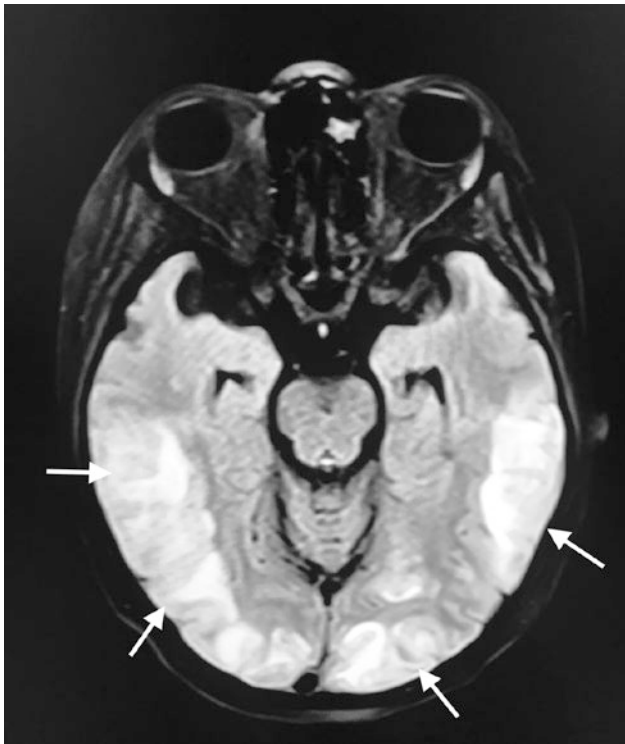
MRI head demonstrating symmetric large confluent areas of abnormal parenchymal T2 FLAIR hyperintense signal (white arrows) prominently involving bilateral temporal lobes (lateral aspects), and bilateral occipital lobes (posteriorly) consistent with the posterior reversible encephalopathy syndrome (PRES)
